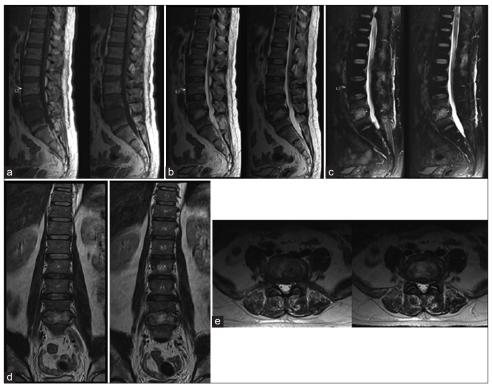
Thoracolumbar MRI of spinal TB in 52-year-old male; (a)T1-weighted image showed isohypointense mass at intervertebral disc L4-L5 and vertebral body of L4-5; (b)T1-weighted image showed isohypointense mass which inhomogeneously enhanced with contrast administration at intervertebral disc L4-L5; (c)T2-weighted image showed isohyperintense mass at intervertebral disc L4-L5 and vertebral body of L4-5; (d) Coronal view; (e) Axial view.
